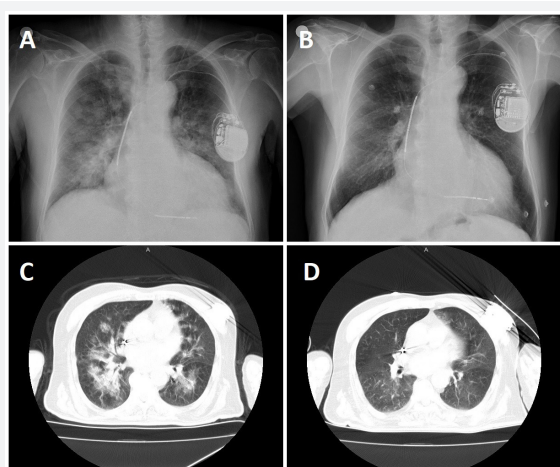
A. Diffuse alveolar density with diffuse opacities on chest X-ray. B. The regression of pulmonary hemorrhage on chest X-ray. C. Diffuse alveolar density on bilateral lungs on thoracic computed tomography. D. The regression of pulmonary hemorrhage on thoracic computed tomography.
